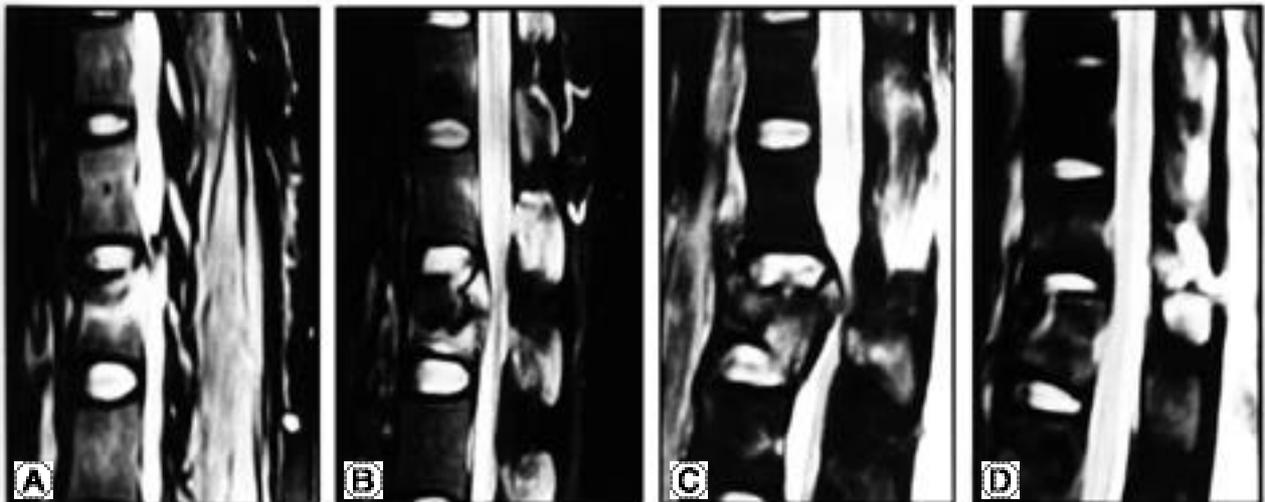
State of the ligamentous structures observed on the MRI examinations. (A) No evidence of injury. (B) Edema in the interspinous space without evident discontinuity or elongation (C) Elongation of the interspinous space without discontinuity (D) Clear disruption of the posterior ligamentous complex
